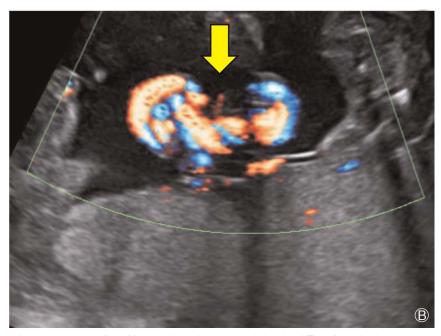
Ultrasound imaging of cord entanglement (arrow) in monochorionic- monoamniotic twins. A Two-dimensional ultrasound at 32 weeks. B Directional color power Doppler at 28 weeks. Reprinted from American Journal of Obstetrics and Gynecology, Vol 213, Hubinont C, Lewi L, Bernard P, Marbaix E, Debiève F, Jauniaux E.S91-S102, Copyright (2015), with permission from Elsevier. 6
